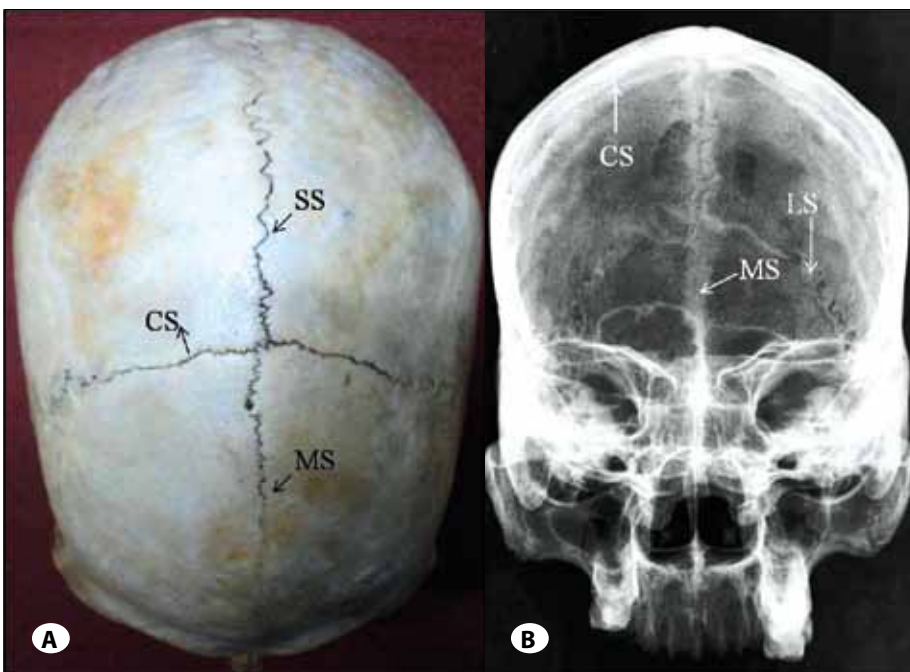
A) Superior view of the skull showing the metopism, B) Anteroposterior radiograph of the skull showing the complete metopic suture. (CS – coronal suture, SS – sagittal suture, LS – lambdoid suture, MS – metopic suture).
